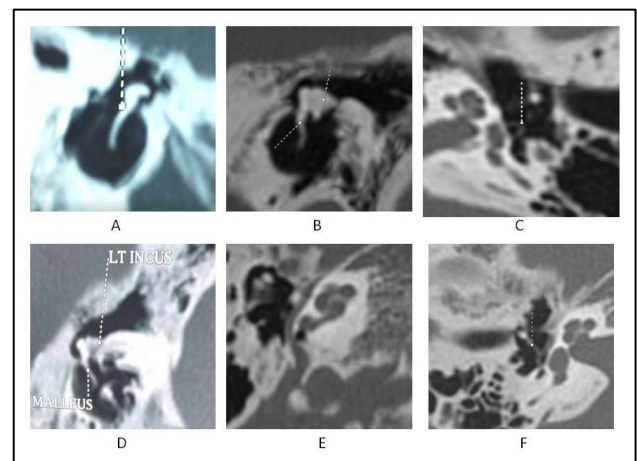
HRCT images of various cases with middle ear ossicular anomalies. (A) Case 1 showing abnormally long handle of malleus on right side; (B) and (C) case 7 showing right normal malleus, stapes crura with absent long process of incus and stapes head; (D) case 10 showing left abnormally large incus with widened long process and fixed with facial canal; (E) and (F) case 11 showing right abnormal course of facial nerve with wide vestibule and part of footplate hanging with rest of ossicular chain.
